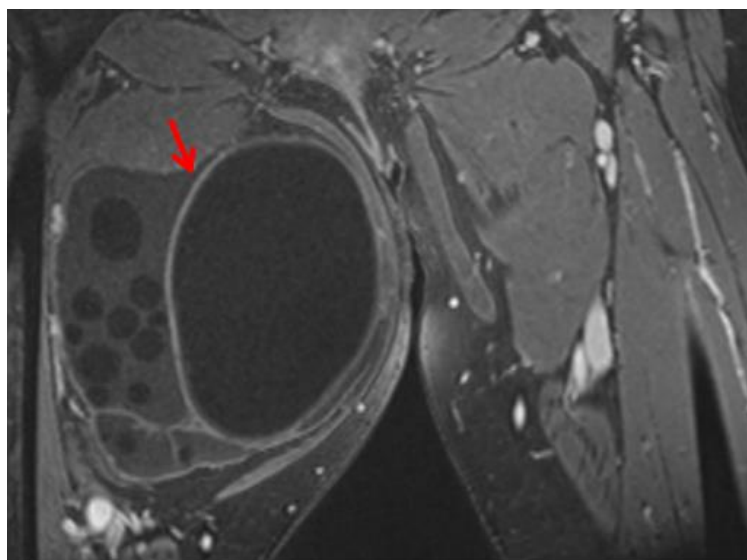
MRI. Coronal section of the left thigh in T1-weighted imaging with fat saturation after gadolinium injection: diffuse pericystic enhancement (arrows)
